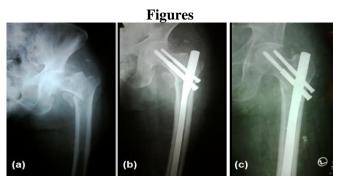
(a) Post traumatic X-ray left hip joint in AP view shows Type A-I fracture of proximal femur (b) Immediate post-operative X-ray (c) Final follow up X-ray with good results.
